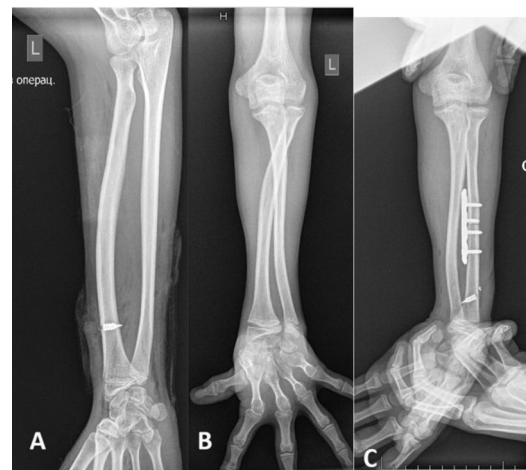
Radiographs of forearm. A) Radius with inserted anchor; B) forearm before surgery; C) anchor into radius, derotation osteotomy, osteosynthesis with locked plate (Chibirov G, 2018)
